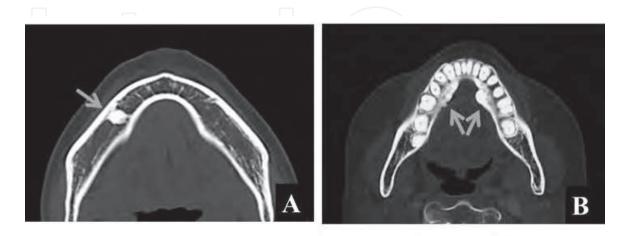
Axial CT images of an osteoma in the mandible (A) and the torus mandibularis (B) (arrows).
